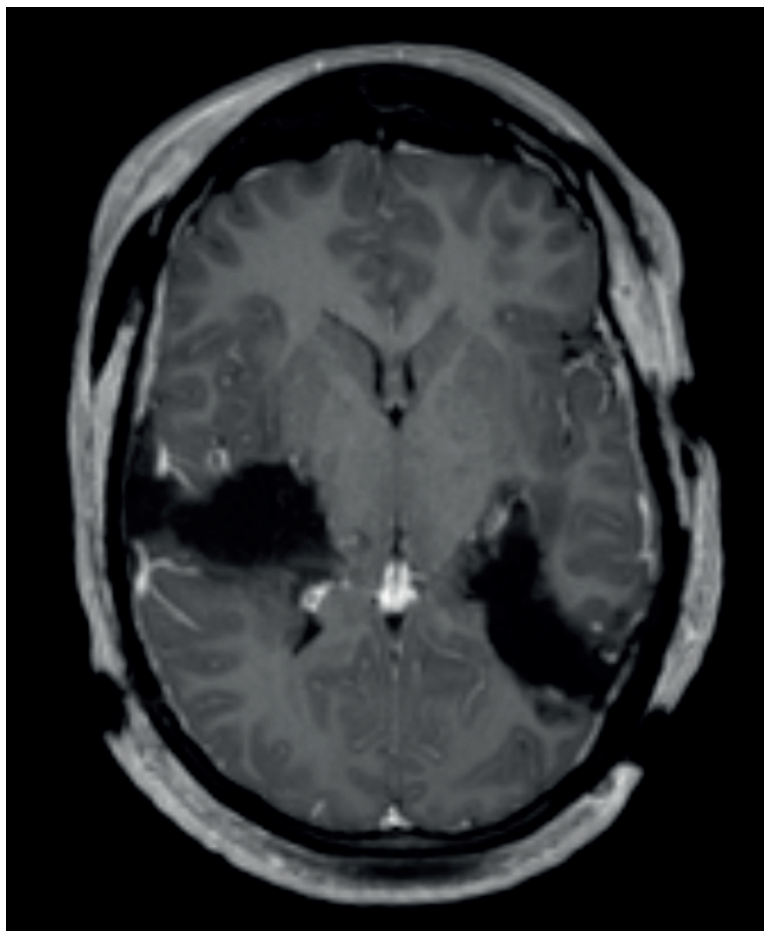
Postoperative MRI with gadolinium showing total excision of both peritumoral lesions.
